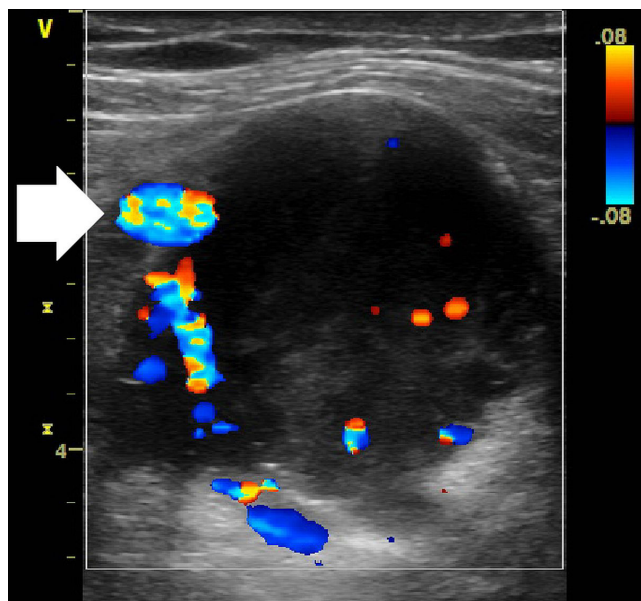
Duplex sonography, axial view, shows the right common femoral artery (arrow). A large circular mass with signs of arterial vascularization is found where the femoral vein is expected.
